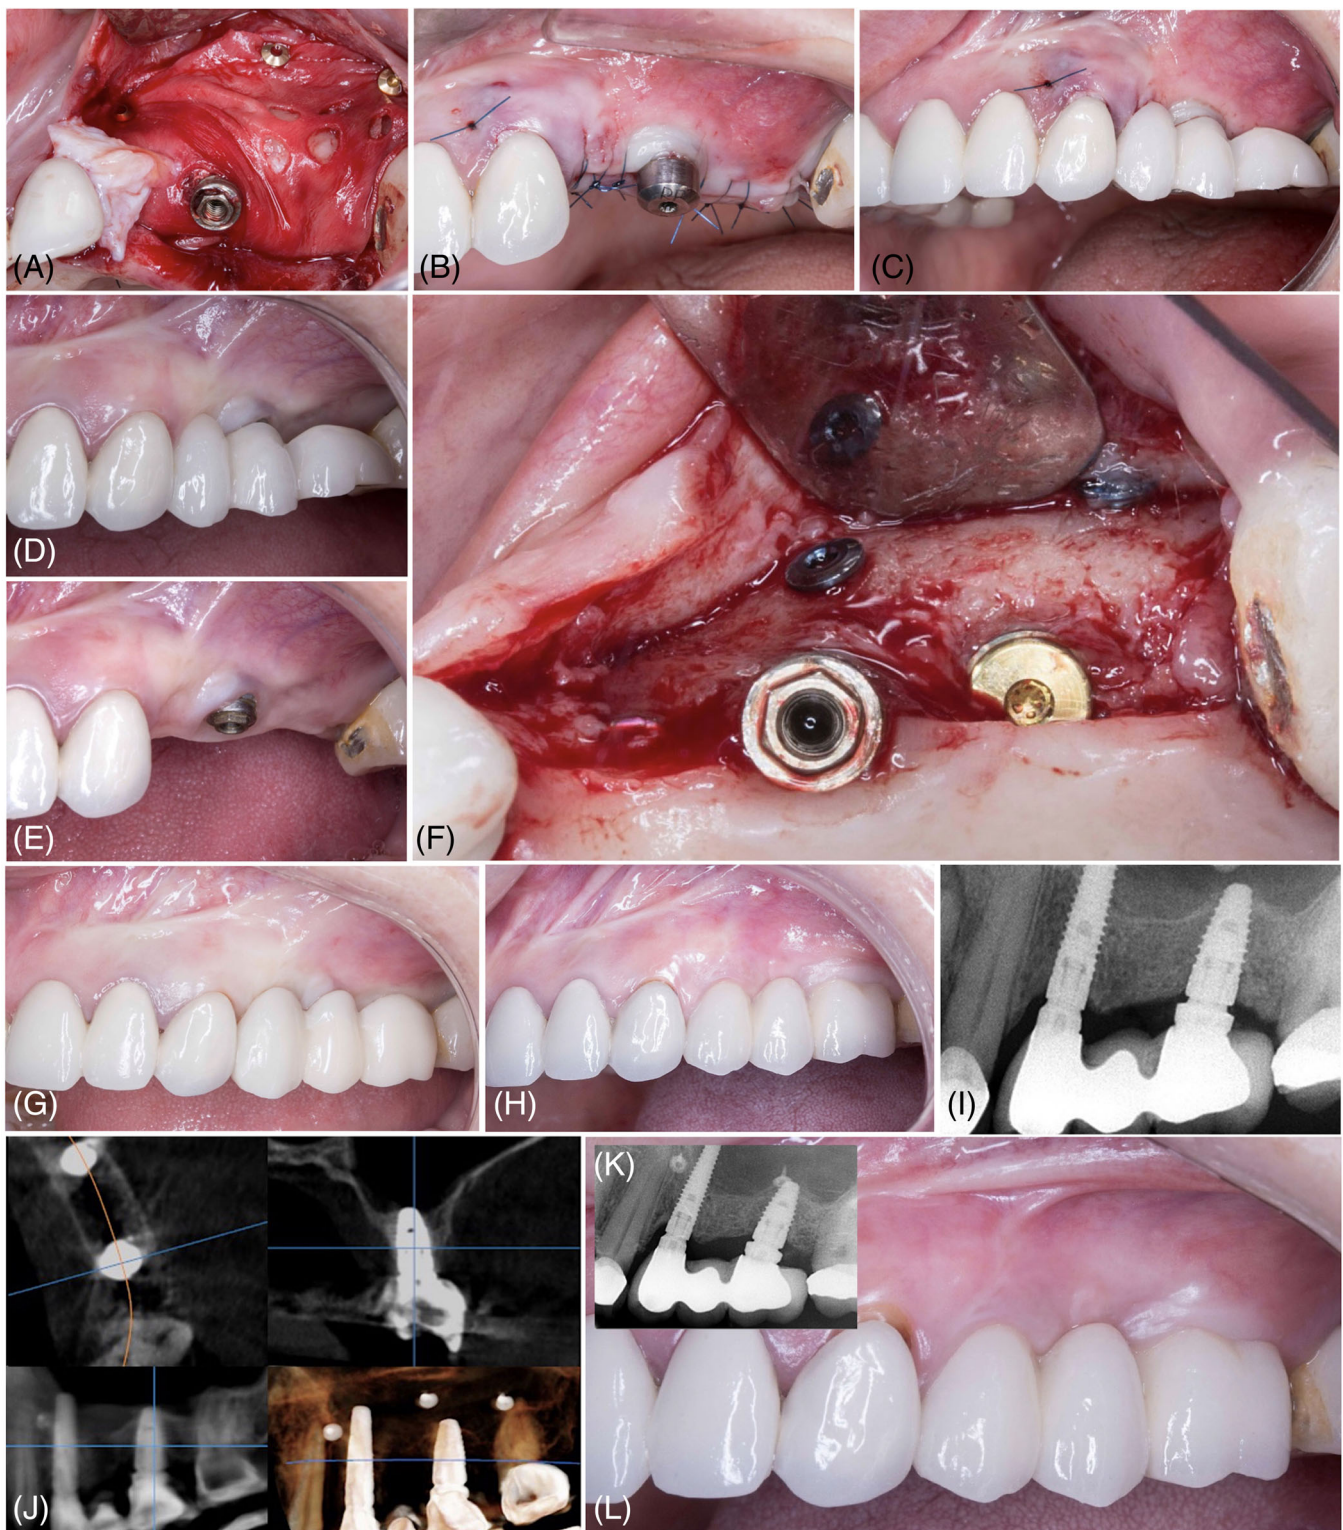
Treatment of horizontal bone defects with simultaneous implantation. (A) The membrane was fixed by metal pins to align the perforations exactly over the autologous bone. A connective tissue graft was harvested from the bone donor site to correct the gingival recession of tooth 23. (B) Primary wound closure without tension. (C) Placement of the same permanent metal-ceramic FPD with reduced occlusion. (D,E) Clinical situation 3 months after the graft and placement of the implants. (F) Reentry at 6 months showing the integration of the TAG. Removal of both the metal pins and the old implant. (G) Aspect of the tissue with a 3-unit implant-supported interim prosthesis. (H) Three years after implant-supported FDP placement. (I,J) Radiographic assessment of the implants at 3 years. (K,L) Clinical and radiographic control showing the maintenance of the soft tissue at 5 years
